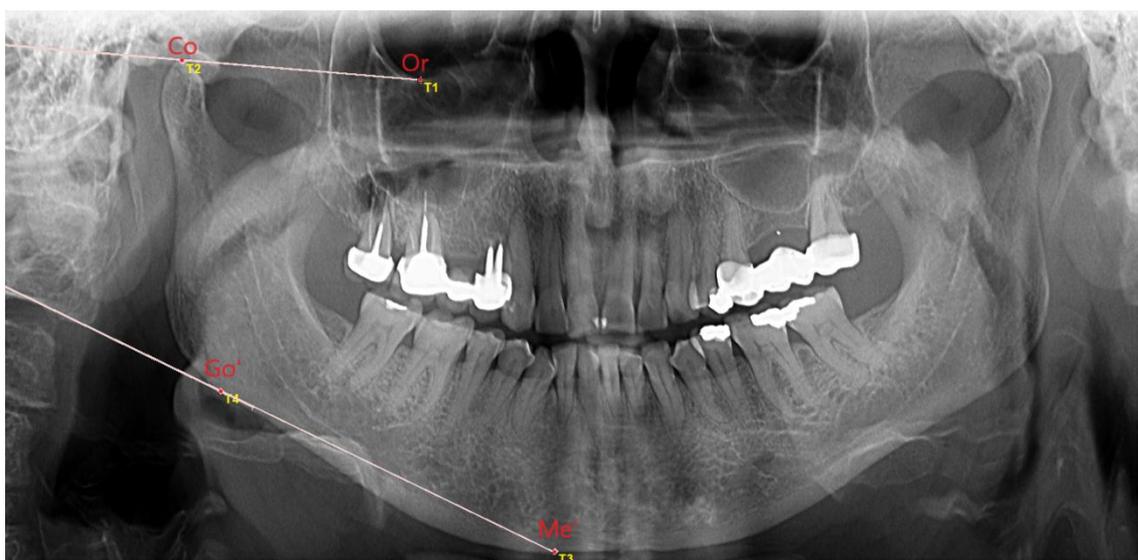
Modified planes in order to measure the skeletal divergence angle on orthopantomogram
